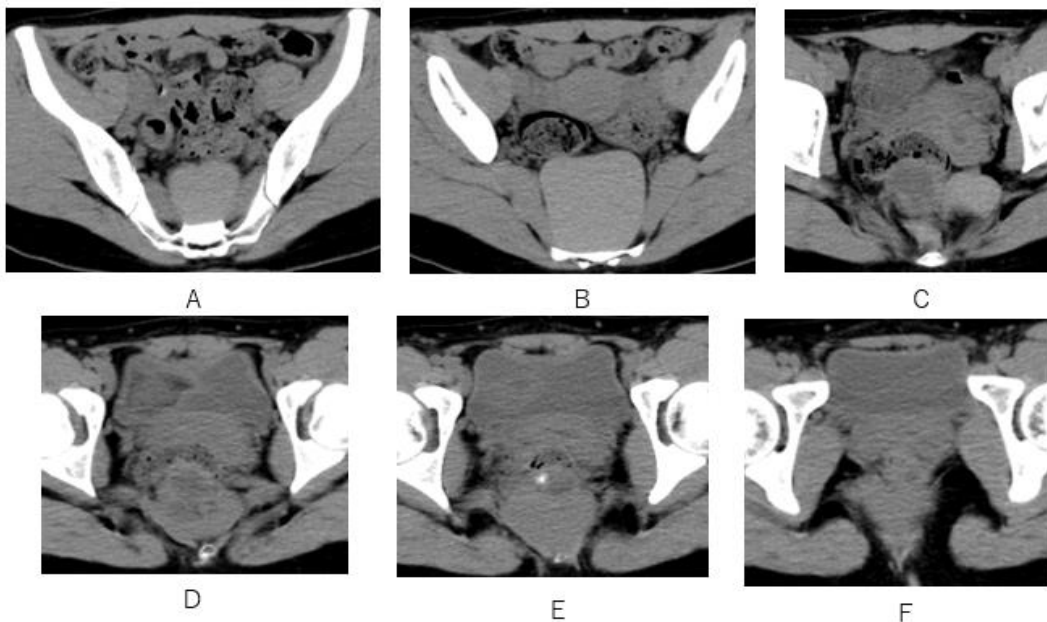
A multi-cystic lesion composed of a homogeneous iso-attenuation cyst (A, B, D-F), low-attenuation cysts (C-E) with calcification (E) is depicted between rectum and sacrum bone on pelvic CT.
